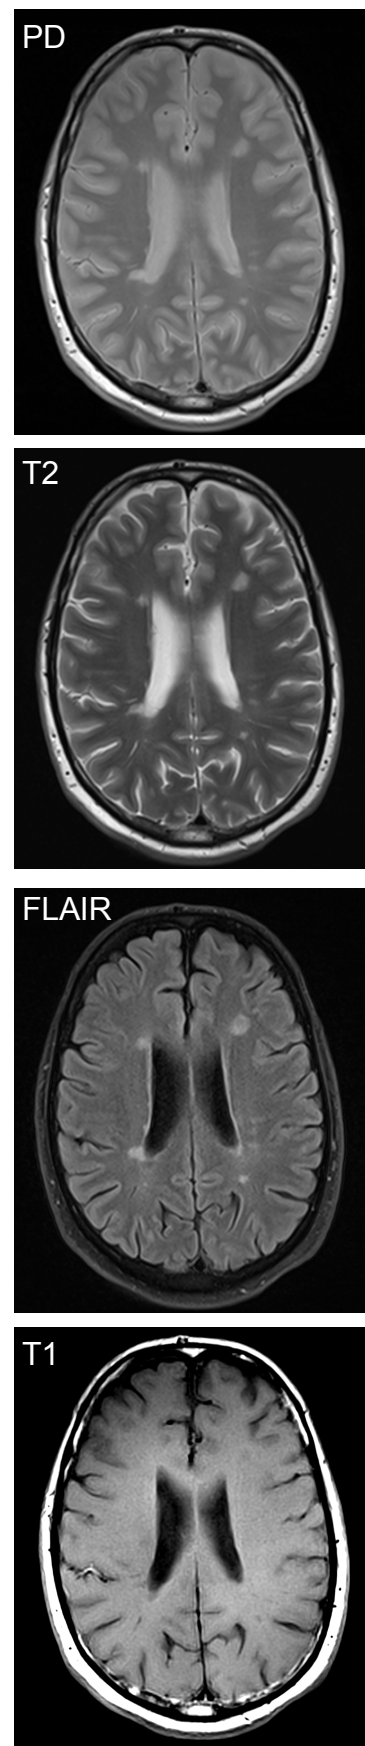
Axial non-contrast MRI in a 49-year-old male MS patient. PD, T2, FLAIR and T1 indicates image type/weighting.
